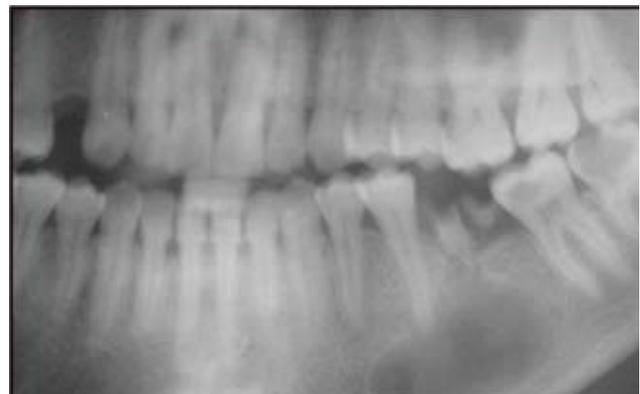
Panoramic radiograph of a radicular cyst in the lower jaw
